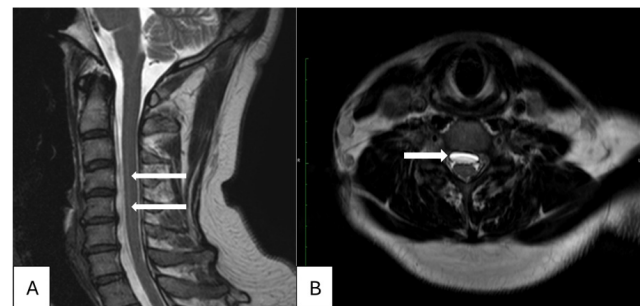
Ventral cervical cerebrospinal fluid (CSF) collection causing anterior spinal cord compression. (A) Sagittal T2-weighted MRI of the cervical spine demonstrating a ventral epidural CSF collection (arrows) displacing the spinal cord posteriorly. (B) Axial T2-weighted image confirming the ventral CSF collection anterior to the spinal cord (arrow), consistent with a neuropathy-associated ventral CSF leak, a structural cause of lower motor neuron syndrome that may mimic ALS
